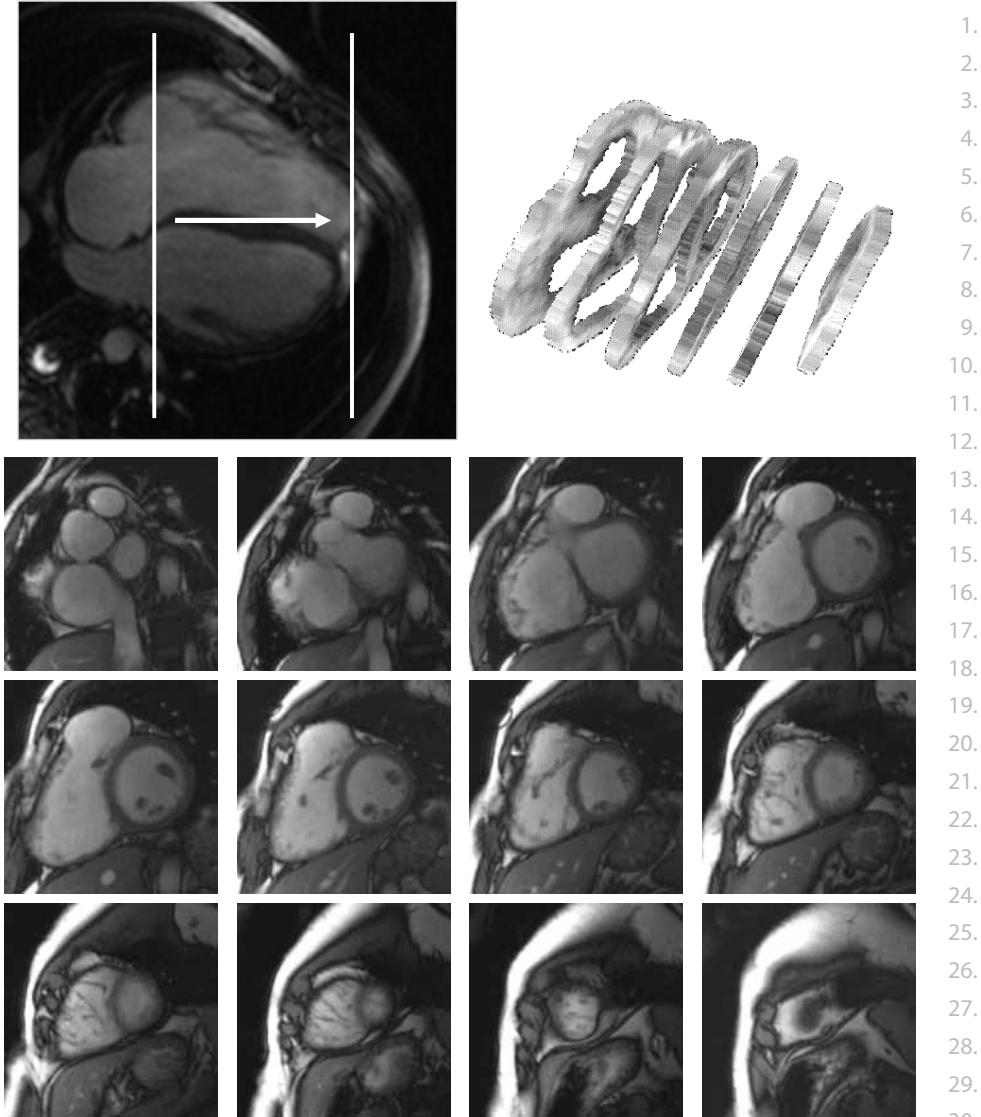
The disc summation method is used for the calculation of right ventricular volumes and ejection fraction by cardiac magnetic resonance imaging.
